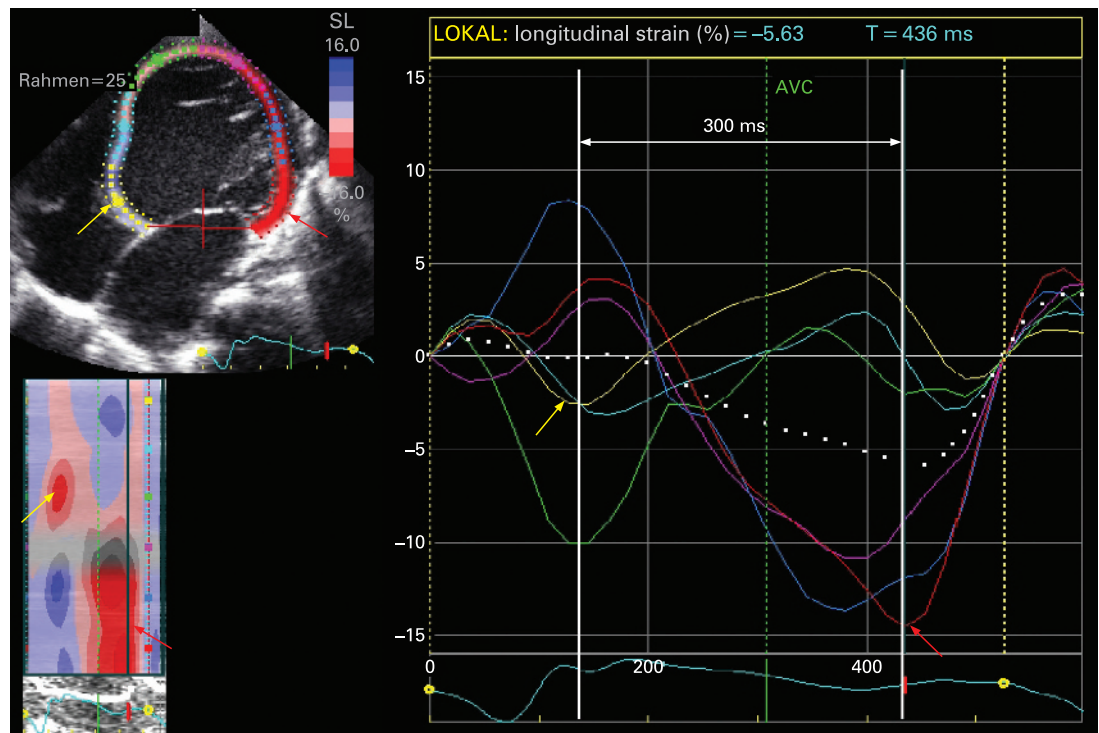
New echocardiographic technique of speckle tracking derived two dimensional strain is able to detect segmental myocardial deformation. The upper left panel displays colour coded left ventricular (LV) segments in the apical four chamber view with corresponding strain curves in the right hand panel (negative strain = contraction; positive strain = relaxation or stretch) and curved two dimensional strain M mode in the lower left panel. During right ventricular outflow tract pacing for complete atrioventricular (AV) block, early contraction appears in the basal and mid ventricular septum (coded yellow and light blue; yellow arrow) causing stretch of the corresponding segments on the LV free wall (coded red and dark blue) followed by late contraction of the latter at the time of septal relaxation (red arrow). This results in an excessive septal to free wall mechanical delay of 300 ms and severe LV dyssynchrony.
